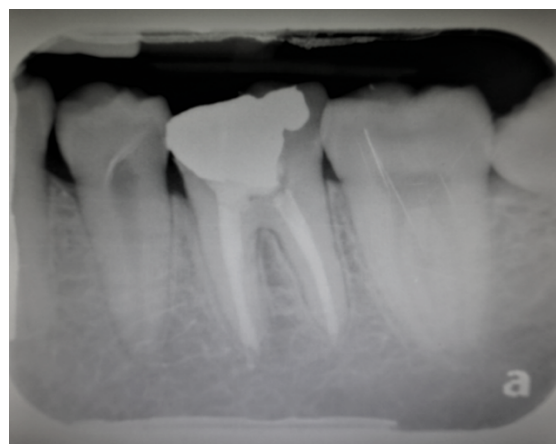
Radiographic image, left lower first molar. Shortened roots are evident, after sound root canal treatment a few years earlier, with no apparent pathological apical lesion.
